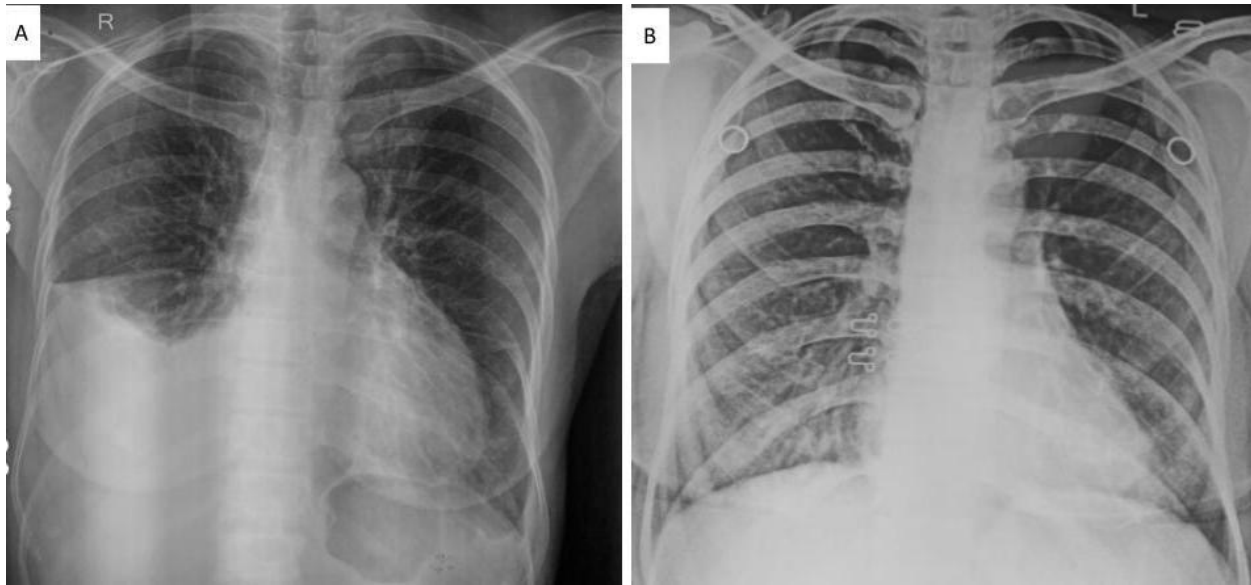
Radiological images of the thorax. Figure (A) shows chest X-ray findings of right-sided pleural effusion with normal lung parenchyma and mediastinum during the second hospital admission. Figure (B) shows a normal chest X-ray at 3 months of follow-up of the last admission.
